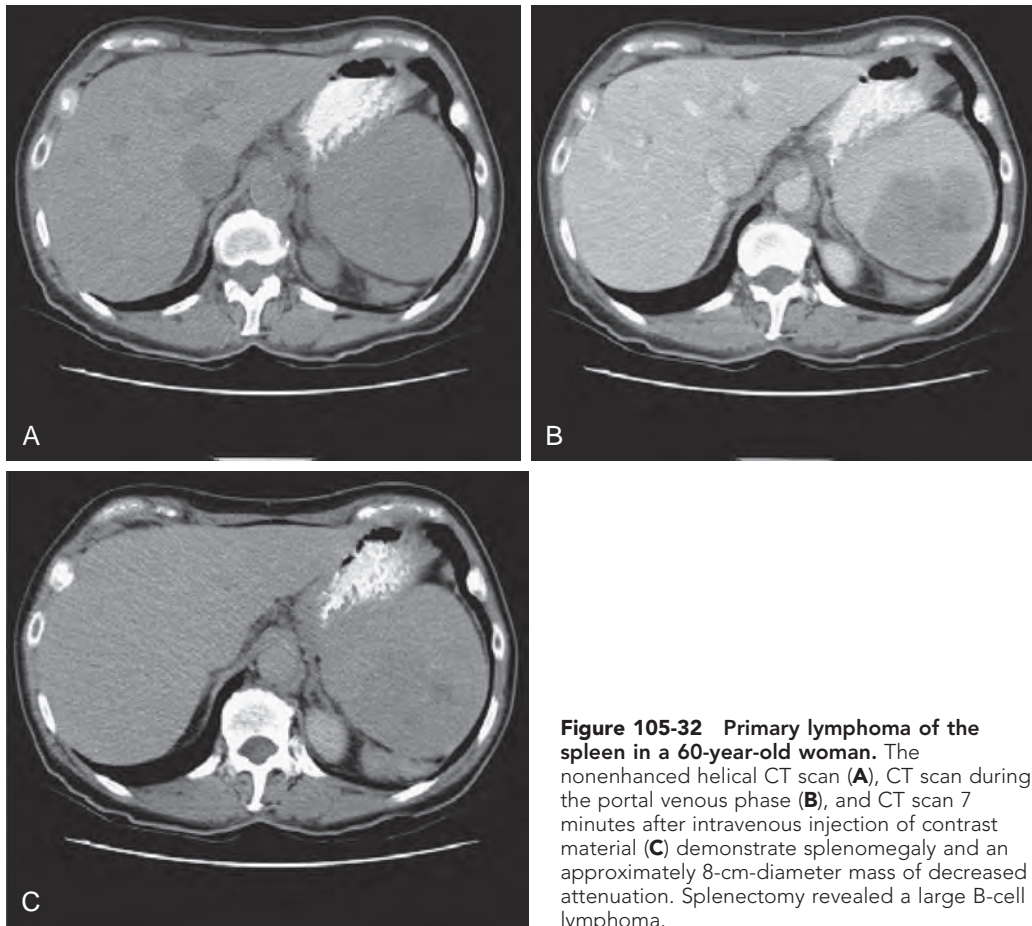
Primary lymphoma of the spleen in a 60-year-old woman. The nonenhanced helical CT scan (A), CT scan during the portal venous phase (B), and CT scan 7 minutes after intravenous injection of contrast material (C) demonstrate splenomegaly and an approximately 8-cm-diameter mass of decreased attenuation. Splenectomy revealed a large B-cell lymphoma.
